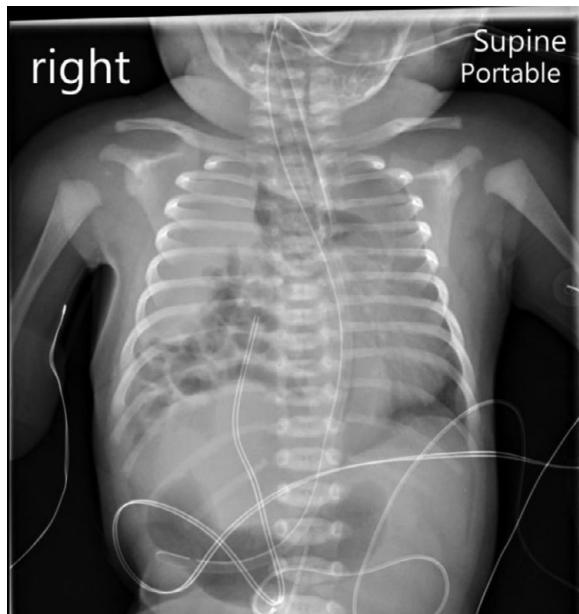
Chest X-ray demonstrating a large right-sided congenital diaphragmatic hernia with herniation of the bowel into the right hemithorax. The right lung markings are absent and the trachea is deviated leftwards. Courtesy of Adam C. Adler MD
